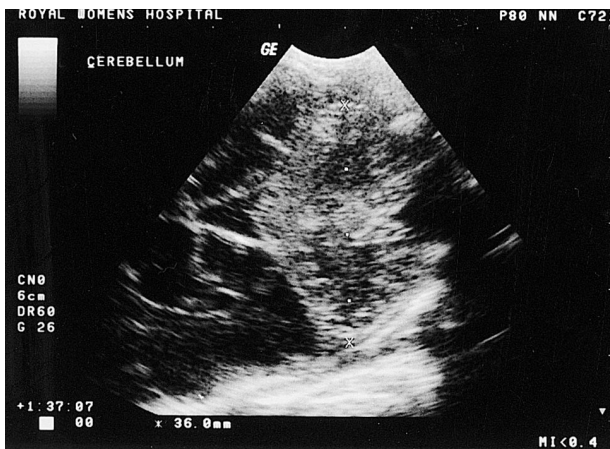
Measurement of transverse cerebellar diameter on cranial ultrasound scan.
